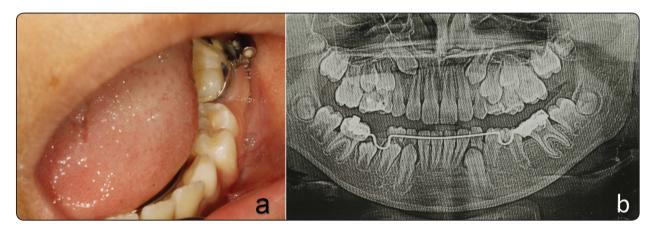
a&b) After 11 months of clinical and radiographic follow up a well-formed bone formation and complete healing as well as spontaneous eruption of the involved 34 (FDI) and 35 (FDI).
